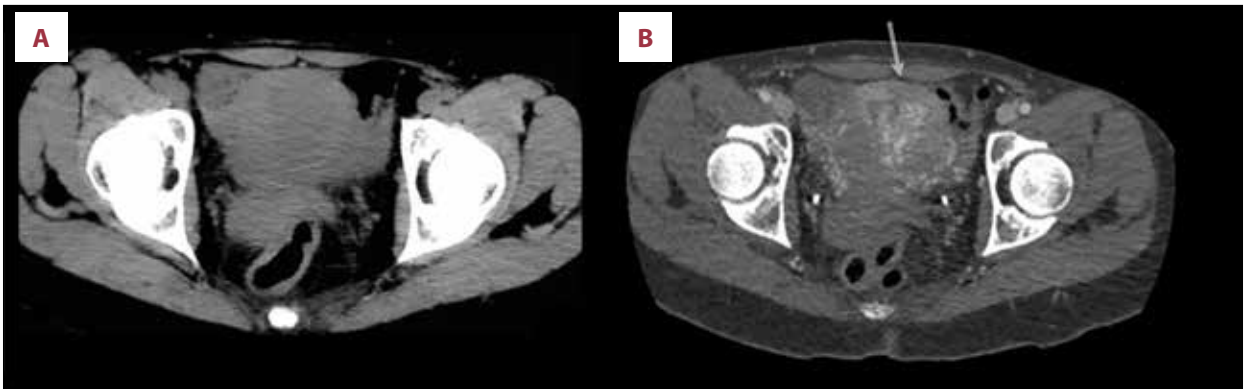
Computed tomography to pre-contrast IV axial scan (A) and post IV contrast arterial phase (B). An increased vascularity area (arrow) inside endometrium and myometrium with arteriovenous structures is recognizable. IV, intravenous.
